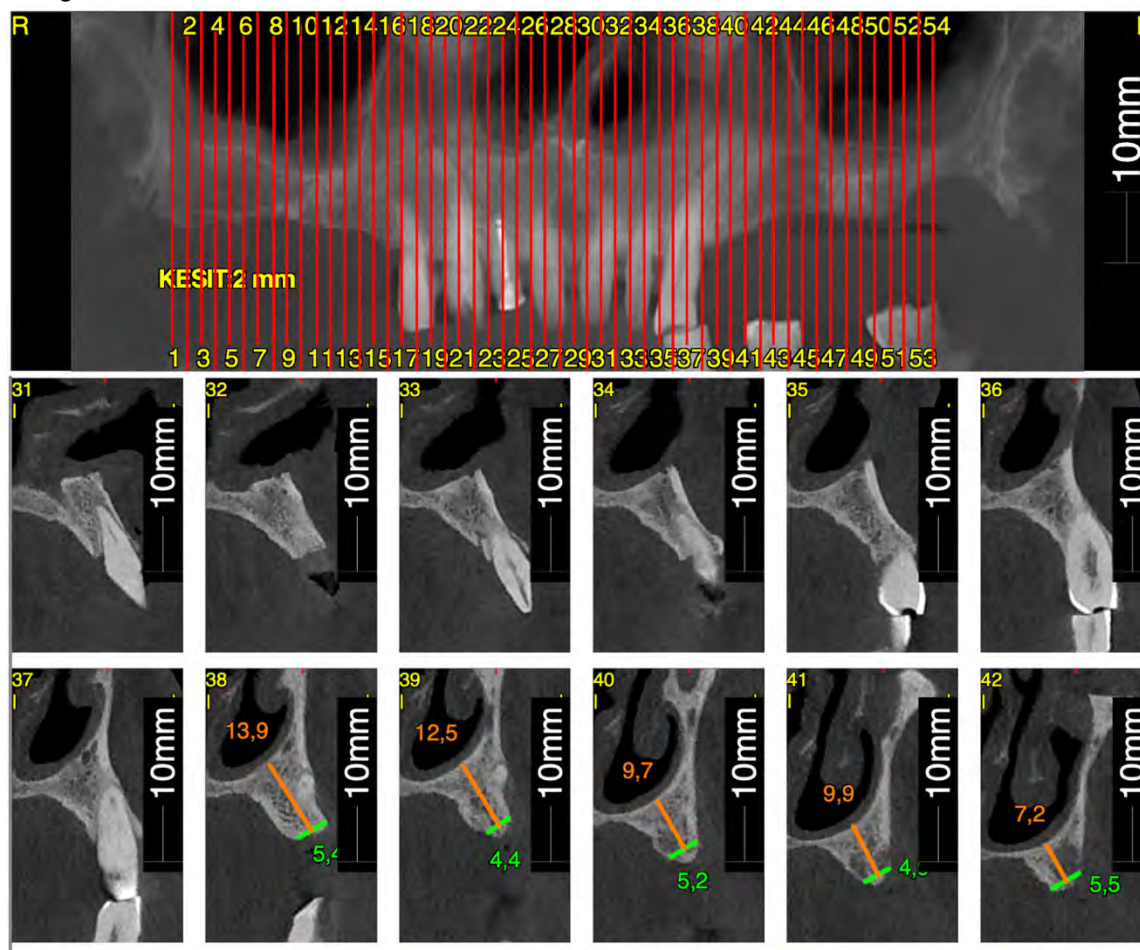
CBCT images 6 months before surgery (sections 39–40, planned area of implant 24).
